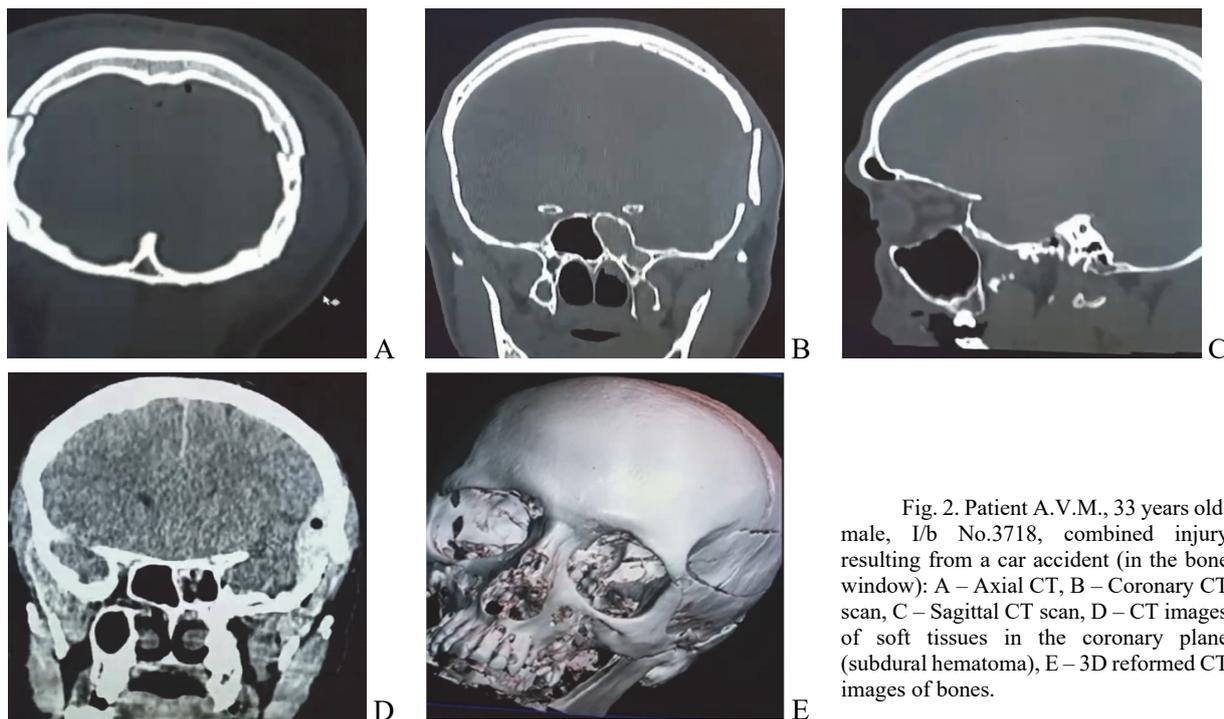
Patient A.V.M., 33 years old, male, I/b No.3718, combined injury resulting from a car accident (in the bone window): A – Axial CT, B – Coronal CT scan, C – Sagittal CT scan, D – CT images of soft tissues in the coronary plane (subdural hematoma), E – 3D reformed CT images of bones.
